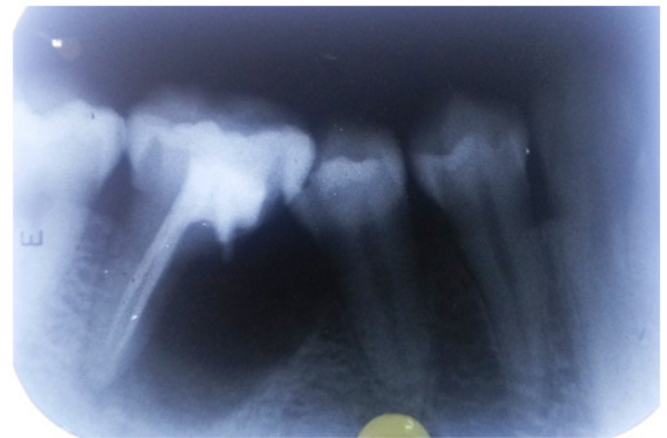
Postoperative radiograph taken a week after surgery.
